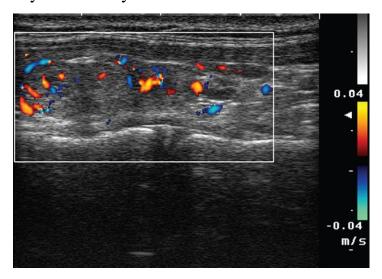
Color Doppler. In color-flow Doppler a unique color is assigned to an individual frequency. Typically a greater frequency shift (corresponding to a higher velocity) is assigned brighter color. Chaudhary and Bano: 2013
